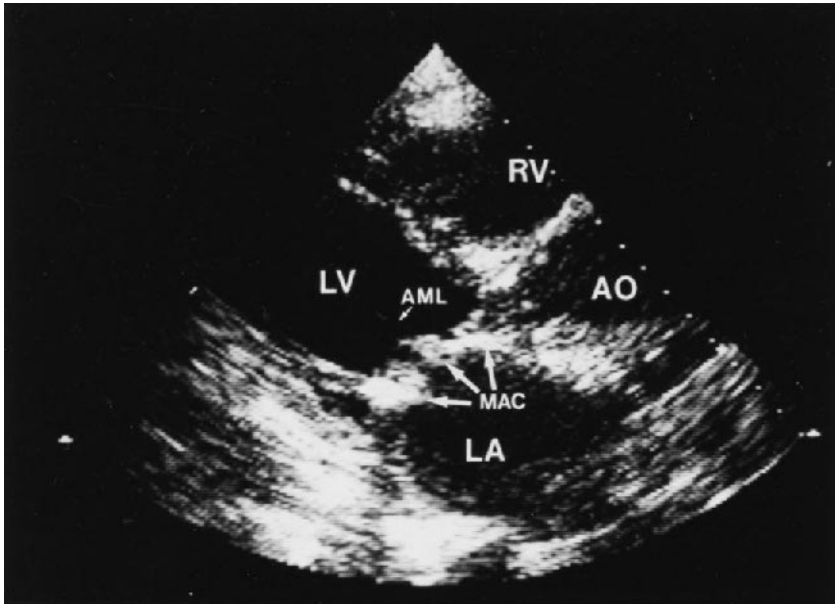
Two-dimensional echocardiogram long-axis view depicting mitral annular calcium (MAC). LA = left atrium; LV = left ventricle; RV = right ventricle; AO = aorta; AML = anterior mitral leaflet.
